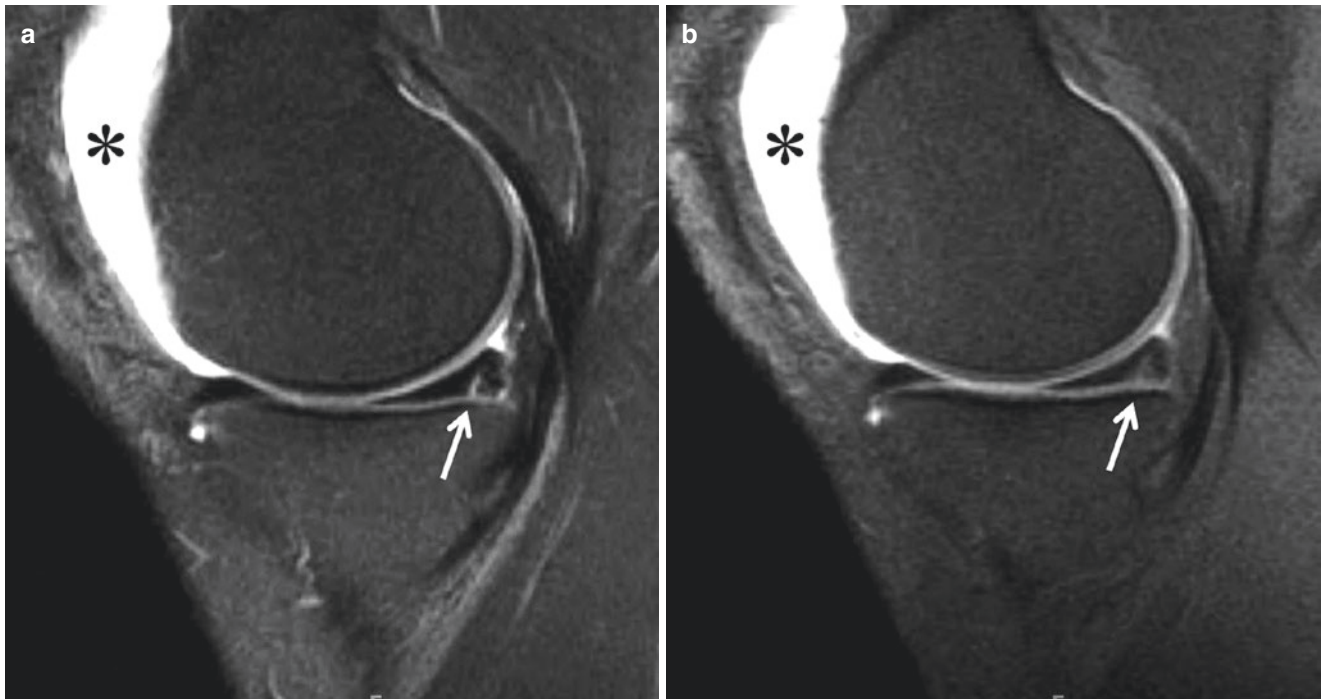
A 32-year-old man with healed meniscal tear, repaired 7 years previously. (a) Sagittal fat-suppressed T2-weighted image shows persistent signal (*arrow*) contacting meniscal surface at site of previously repaired peripheral longitudinal tear. Abnormality is bright
